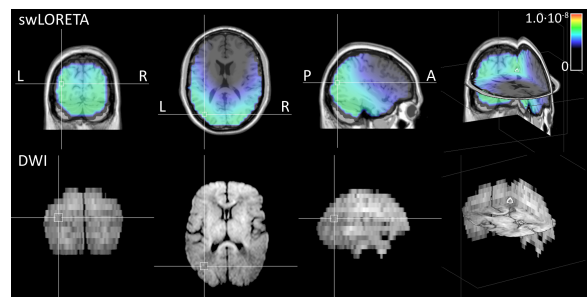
swLORETA reconstruction of EEG recording with a segment length of 35 min. The color bar indicates current density probability, with red and black representing high and low probability, respectively. Note that the L-R orientation of the MRI image is changed from the international standard to facilitate comparison with the current density distribution.
